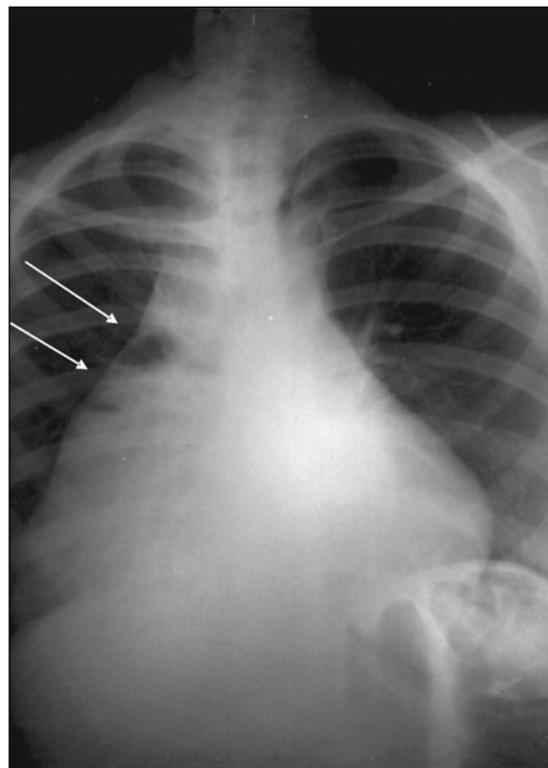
Chest radiograph postero-anterior view performed at admission. The image in upright position suggested an enlarged mediastinum with an unclear right-sided heart limit and multilevel hydroaerial images
